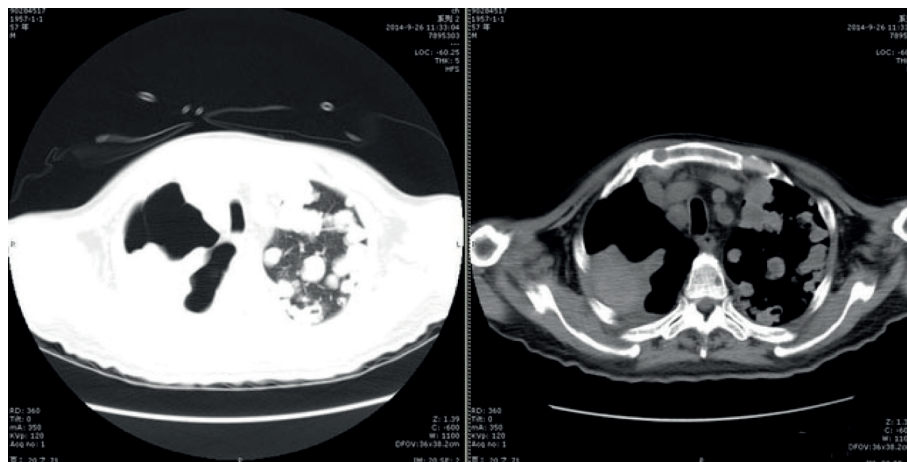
The NSCLC patient is a female aged 56 years old. CT signs suggest that nodules and lumps often occurred in patients at varying sizes and uneven density exist in the pleural cavity. Multiple mediastinal lymph nodes and fuzzy plaque shadows can be seen, which are considered as tumor metastasis accompanied with pulmonary infection.
